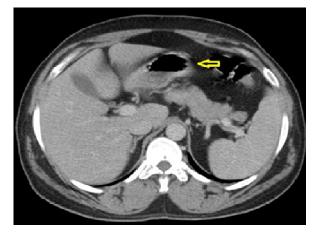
Computed tomography of abdomen (axial cuts) showing a subcentimetric polyp in greater curvature of stomach (yellow arrow)
